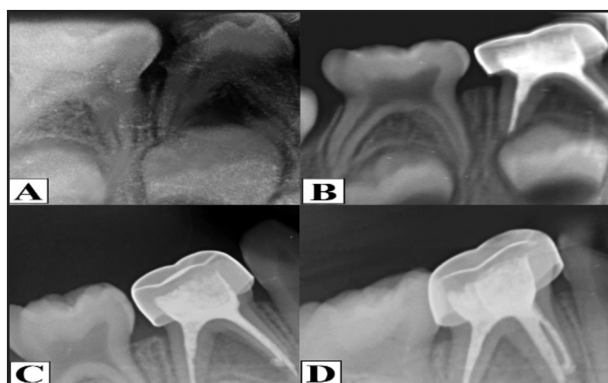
(A) Preoperative, (B) Postoperative, (C) After three months follow up and (D) After six months follow up radiographs for Hesperidin and Zinc oxide pulpectomy in mandibular first primary molar.
